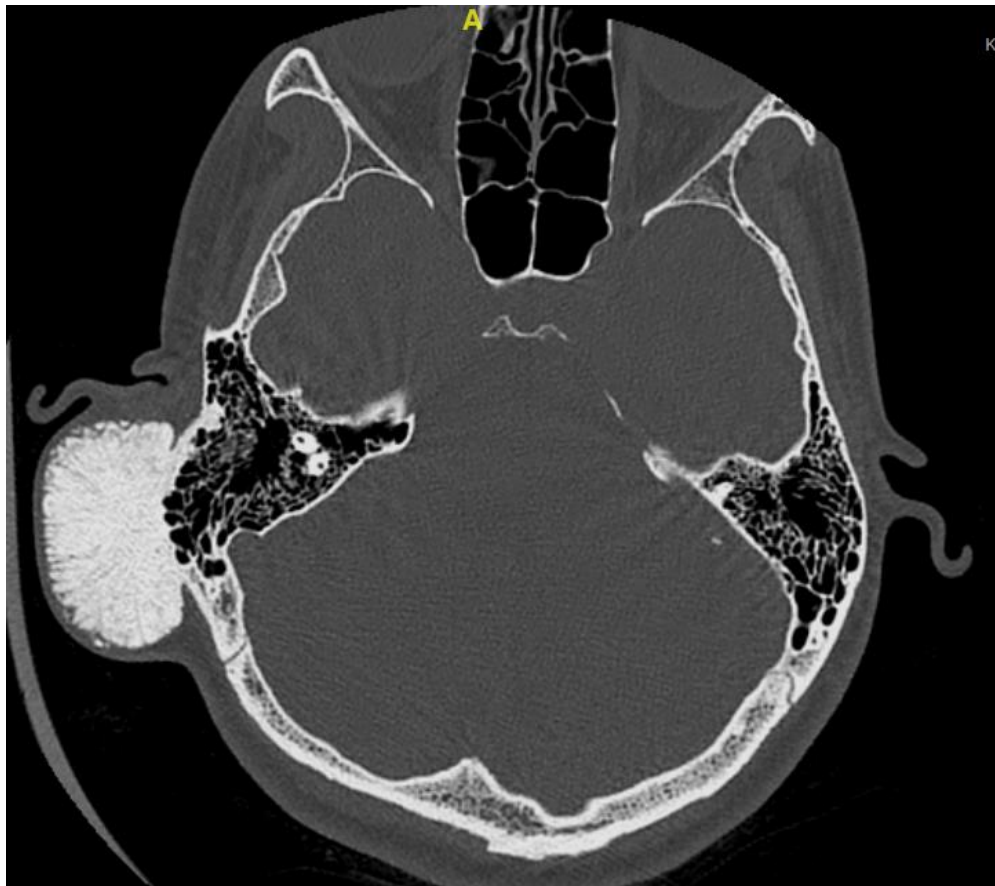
Axial native CT Scan image showing a bony homogenous round mass with a clear border and narrow attachment to the mastoid on the right side.
